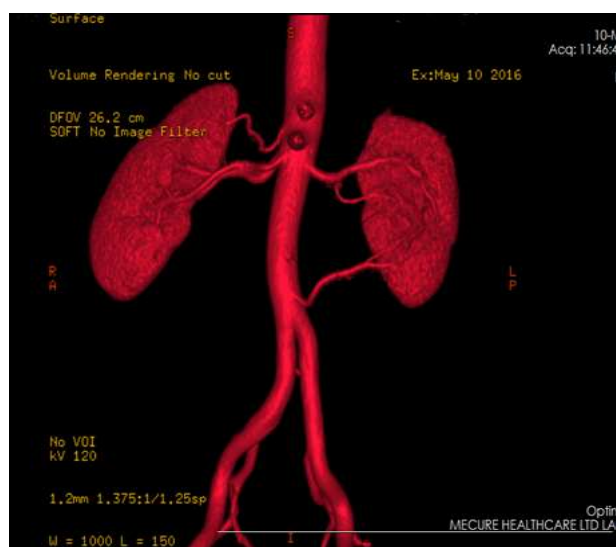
showing donor CT angiogram with multiple vessels in both kidneys
